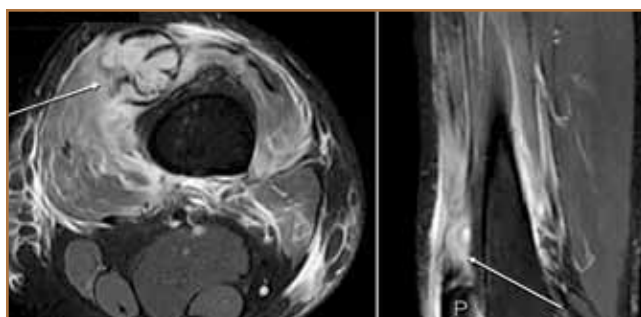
T₂-weighted magnetic resonance imaging shows disrupted quadriceps tendon (arrows) with fluid signal. Axial view shows increased signal in surrounding muscles. Sagittal view shows some quadriceps tendon fibers still attached to patella (P).
